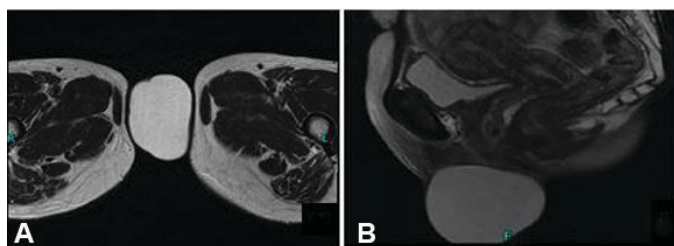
T2-weighted MRI images in (A) axial and (B) sagittal demonstrate a well-defined, exophytic lesion that returns high intensity signals.
